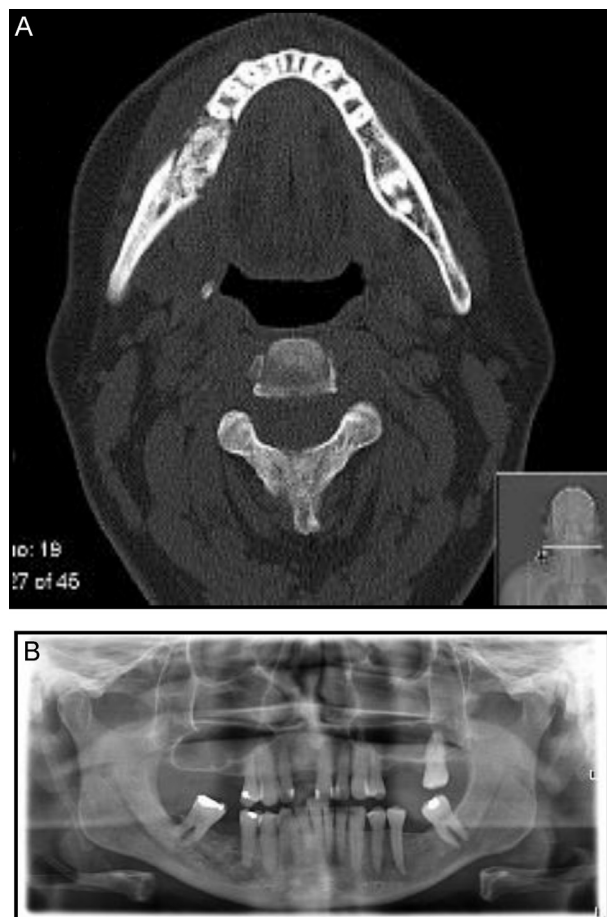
(A) Face CT: marked change in the bone trabeculation of the body of the jaw to the right, about 3.5 cm long and (B) orthopantomography showing changes on right jaw.
